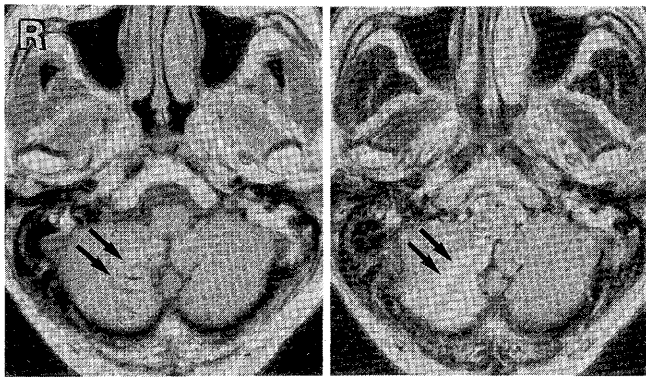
Magnetic resonance images at 2 months after ictus showing cortical laminar necrosis in the right medial inferior cerebellum (arrows). *left*: T₁-weighted spin-echo image (repetition time 632 msec, echo time 16 msec, number of excitations 2). *right*: T₂-weighted fluid-attenuated inversion recovery image (repetition time 7500 msec, echo time 145 msec, inversion time 1750 msec, number of excitations 4).
